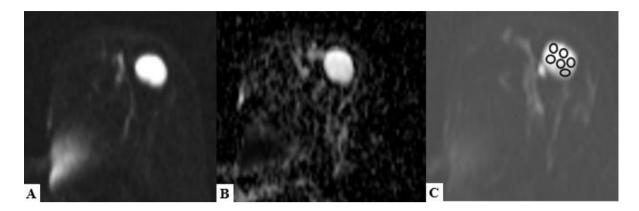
DWI & ADC sequences of a patient with fibroadenoma: (A) DWI and (B) corresponding ADC images showing no restriction of diffusion within the lesion present in left breast – suggestive of benign etiology (C) DWI image demonstrating the method of placing multiple ovoid ROIs (each measuring ~ 25 mm²) throughout the benign lesion for calculation of mean ADC value.
